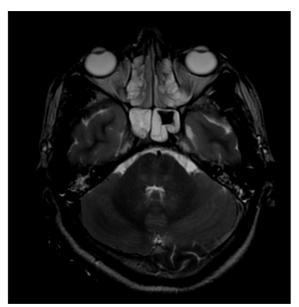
MRI scan case 1(Bilateral abnormal signal in inferior pons)
